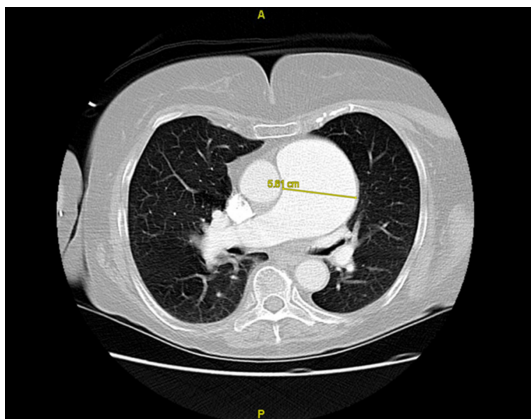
Cross section of the CTA chest showing aneurysmal main pulmonary artery measuring up to 5.6 cm in diameter.
